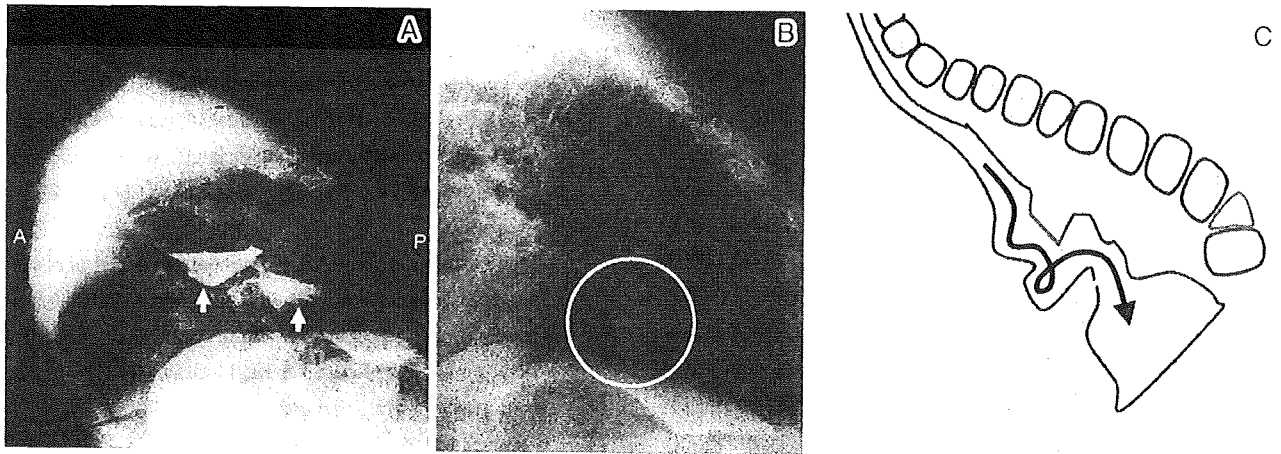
The lateral X-ray films show the contrast media (A: arrow) or the contrast capsule (B: circle) that were located in the esophagus. C: the montage of the patient's esophagus; the arrow indicates the path of entry of the tablets into the stomach. The contrast media remains in the esophagus during the esophagography procedure (more than 5 min). The contrast capsule reaches the stomach after 15 min. These data support the fact that the LD-CD tablet remains in the esophagus after swallowing.
